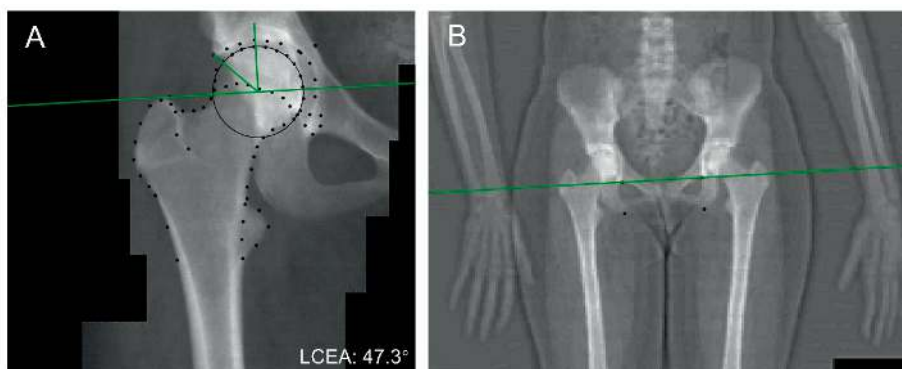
The measurement of lateral center edge angle (LCEA). On the hip dual-energy x-ray absorptiometry (DXA) image, we outlined the shape of the proximal femur and acetabulum with 80 landmarks. The center of the femoral head was automatically determined by the best-fitting circle, which was based on the landmarks outlining the femoral head. The LCEA of 47.3 degrees in this sample (A) is formed by the intersection of two lines: one from the center of the femoral head to the most lateral bony edge of the acetabulum, and the other from the center of the femoral head perpendicular to the horizontal reference line of the pelvis as determined on the full-body DXA image (B).
